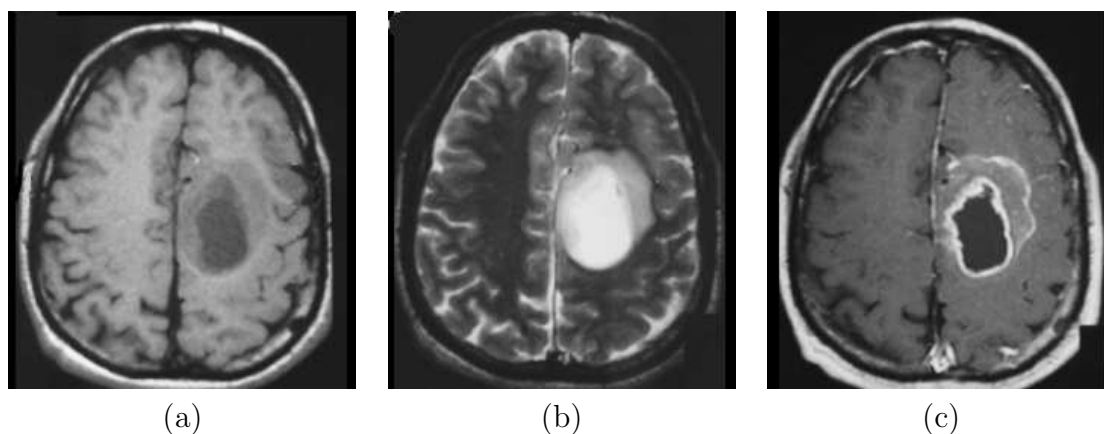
A cystic oligodendroglioma. a) Axial T1-weighted, showing varying degrees of hypointensity. b) T2-weighted image showing hyperintensity, especially of the central cyst. c) Contrast enhanced T1-weighted image showing ring formation at both the tumor-cyst, and tumor-brain interfaces. [Engelhard et al., 2003].
